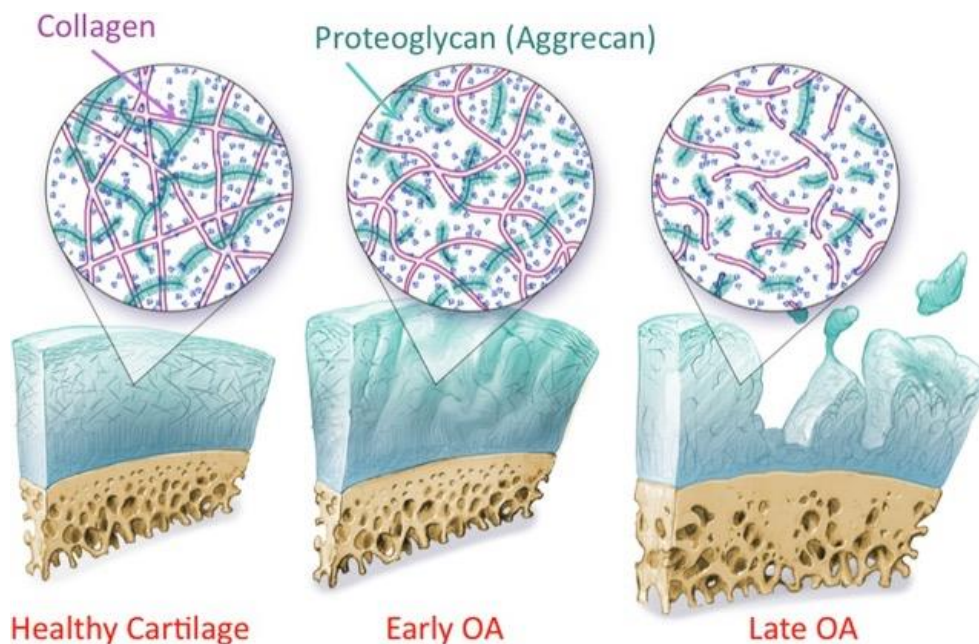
Stages of osteoarthritis (OA)-related articular cartilage degeneration. Early-stage OA degeneration includes increased hydration, proteoglycan loss, and thinning or disruption of the collagen network. Late-stage OA degeneration includes decreased hydration and extensive fibrillation and cartilage thinning. Figure reproduced with permission of Wiley, from Quantitative MRI of articular cartilage and its clinical applications.²⁸
